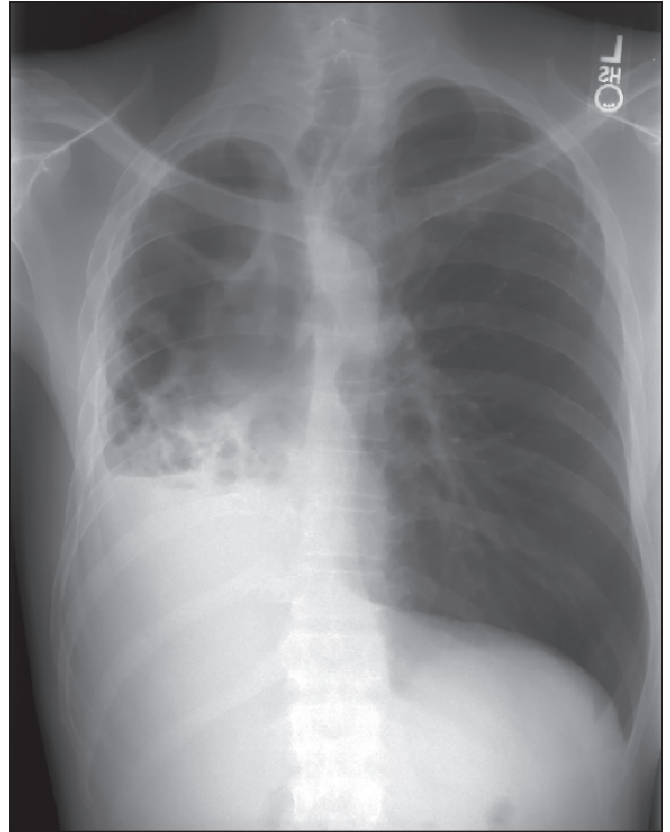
Postero-anterior chest radiograph in patient 5 shows underlying chronic obstructive pulmonary disease with severe volume loss and fibrocavitary disease in the right lung.
